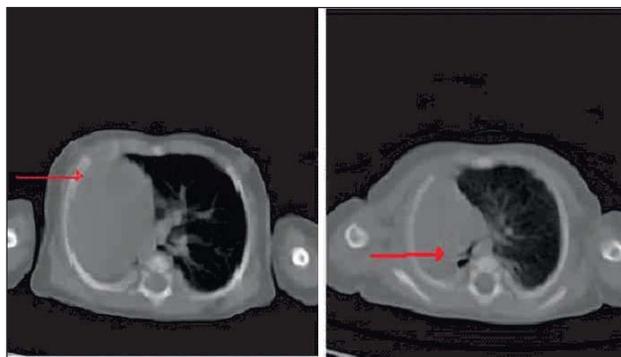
CT chest showing right sided volume loss, mediastinal shift to the right side and dextroposition of the heart.
